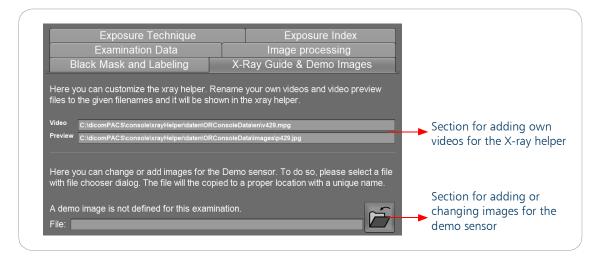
Tab "X-ray Guide & Demo Images"
